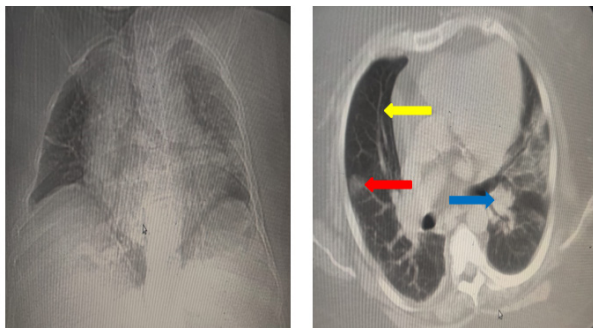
A 63-year-old male; (a) CXR, AP view (b) Chest CT, Axial view (c) Chest CT, coronal view
